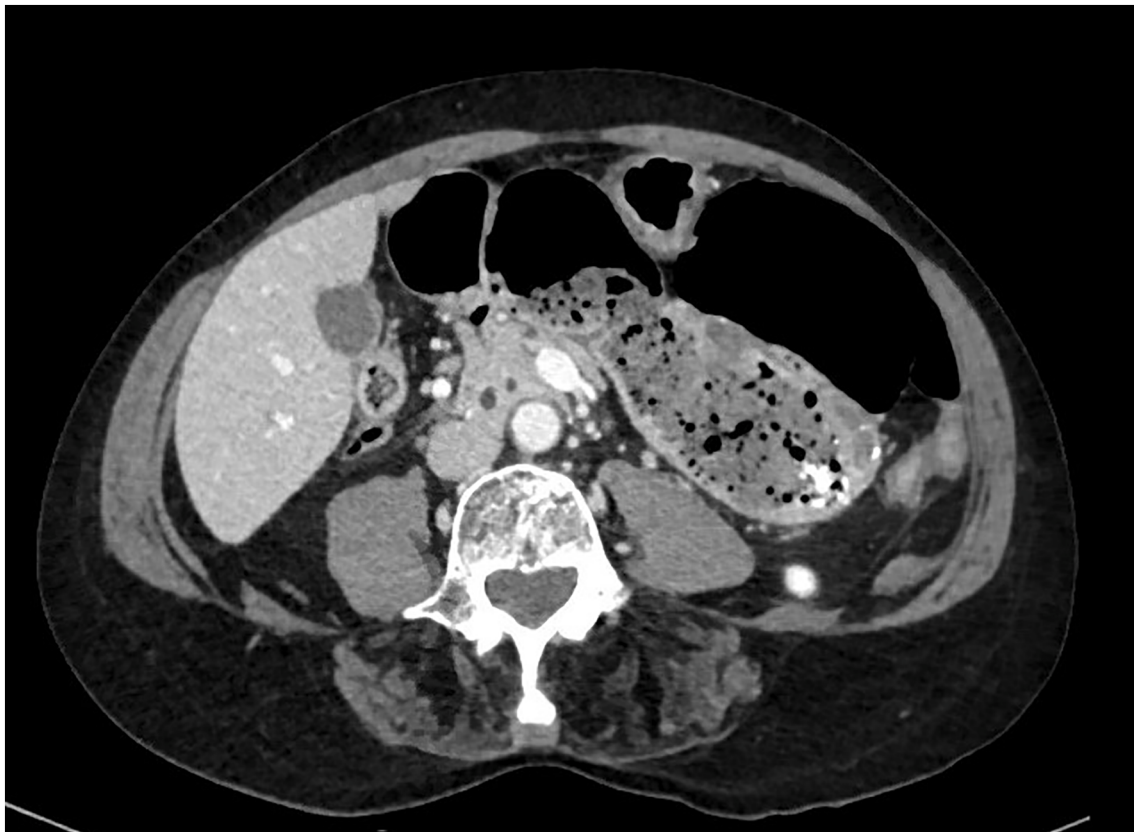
Axial CT scan showing the colon herniating posterior to the stomach and through the Foramen of Winslow.
